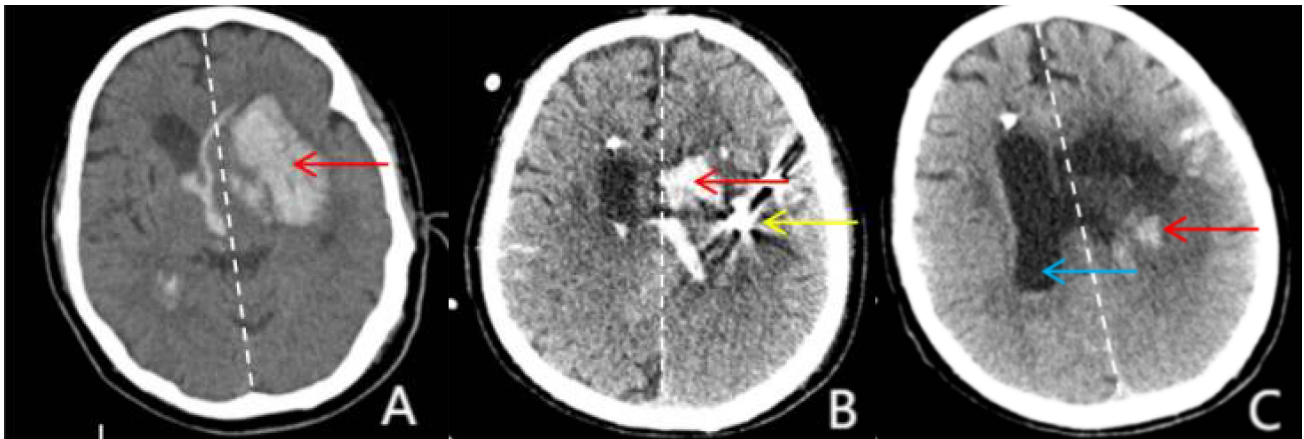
Hematoma changes. (A) CT on admission shows Compression by a left-sided hematoma (red arrow) causes brain tissue to shift to the right, with the midline (dotted line) displaced to the right (red arrow), indicating the formation of a subfalcine herniation. (B) Postoperative CT after SMIS shows a relative improvement in the midline (dotted line) compared to that in (A), with a significant reduction in hematoma residuals (red arrow). The stereotactic puncture needle (yellow arrow), placed during surgery, is visible and used for drainage or decompression. (C) Postoperative CT after removal of the puncture needle: The midline (dotted line) appears to have returned to near-normal alignment, indicating significant relief of brain herniation symptoms. The hematoma (red arrow) was nearly completely absorbed, and the right lateral ventricle (blue arrow) reappeared, suggesting that the compression of the lateral ventricle was resolved. CT, computed tomography; SMIS, stereotactic minimally invasive surgery.
